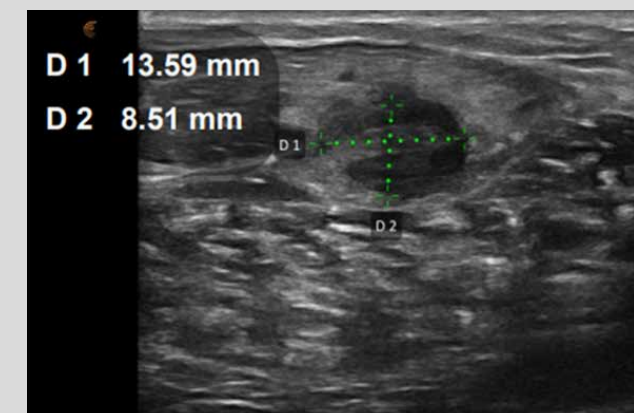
Ultrasound 4 weeks after injury
